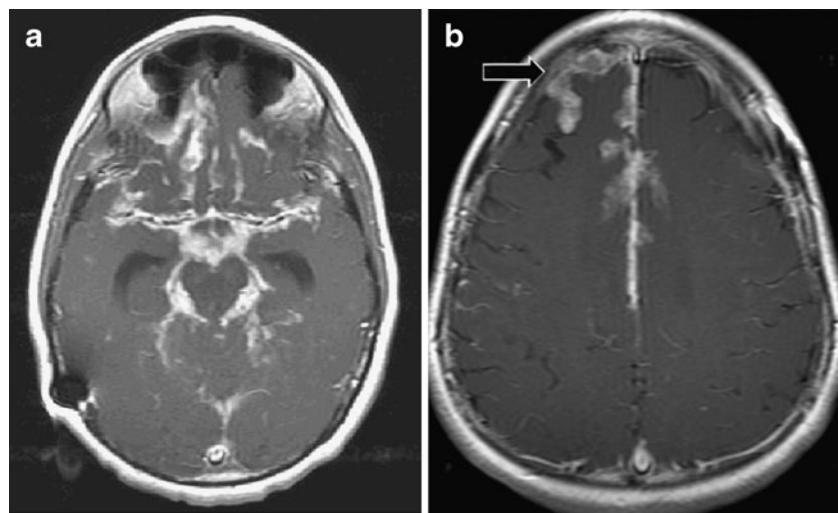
a T1-weighted axial MRI scan of the brain with contrast revealing extensive intense leptomeningeal thickening and nodular enhancement along the basal cisterns in the posterior fossa including the suprasellar, preopticine, ambient, and cerebellopontine angle
